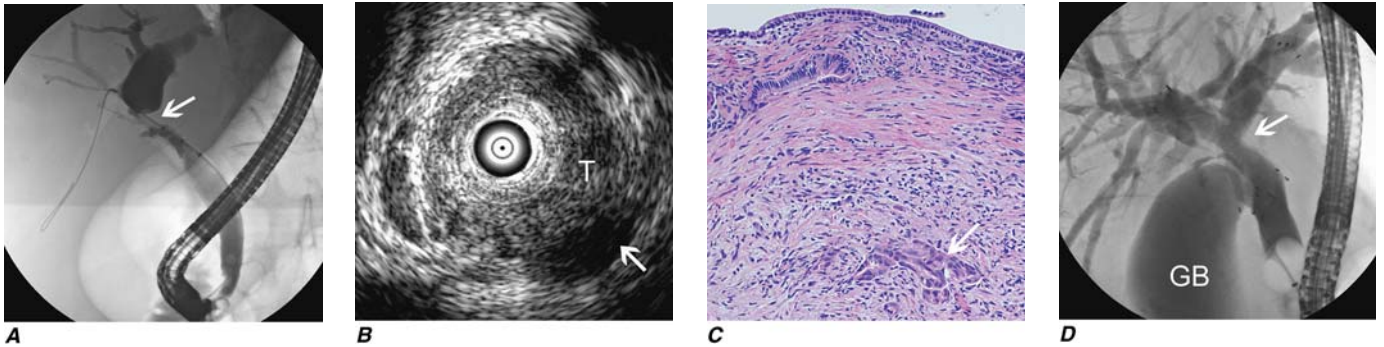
FIGURE e25-11 Endoscopic diagnosis, staging, and palliation of hilar cholangiocarcinoma. A. ERCP in a patient with obstructive jaundice demonstrates a malignant appearing stricture of the biliary confluence extending into the left and right intrahepatic ducts. B. Intraductal ultrasound of the biliary stricture demonstrates marked bile
